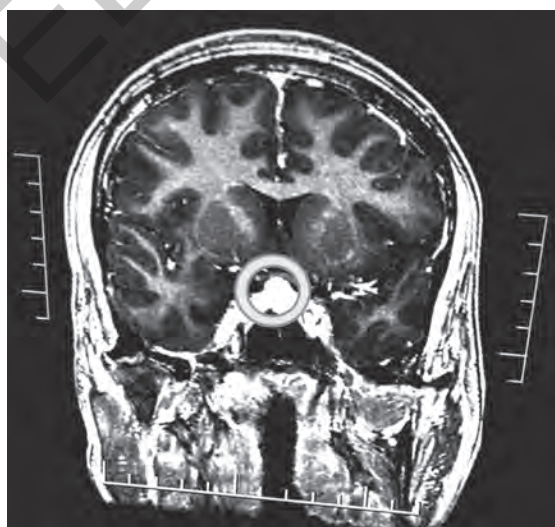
Post contrast MRI at diagnosis. Note the thickened stalk and homogenously enhancing pituitary
